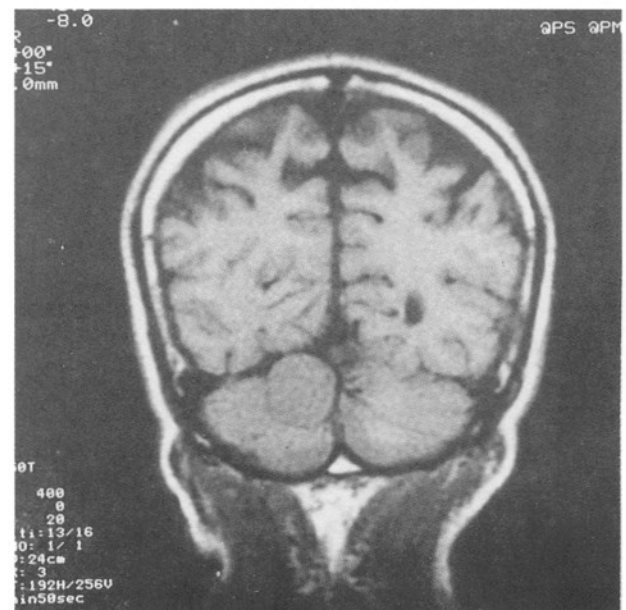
MR images, demonstrating the tumour on coronal T1-weighted image. Note also the intensity and location of the tumour.
